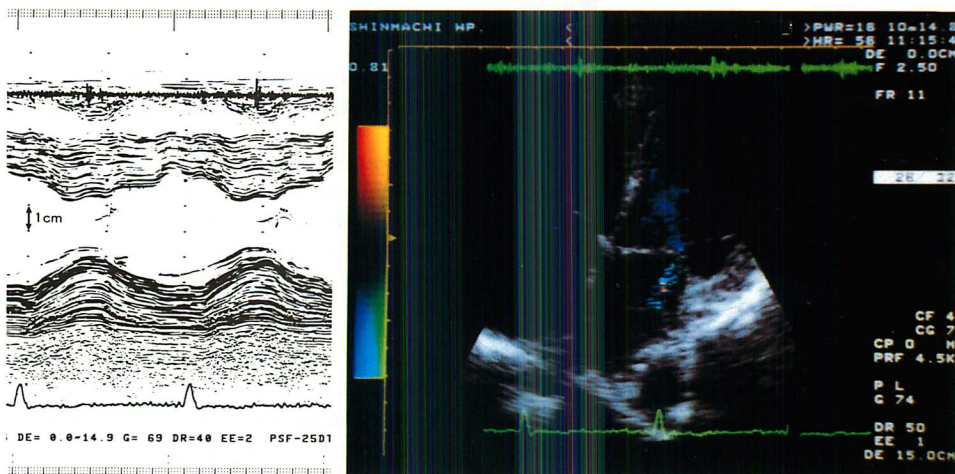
M-mode and two-dimensional color Doppler echocardiograms of a 44-year-old woman with biopsy-proved cardiac amyloidosis and nonrestrictive ventricular physiology. Ventricular septal wall thickness and posterior wall thickness are increased, but fractional shortening is normal. A mild mitral regurgitation is observed.
